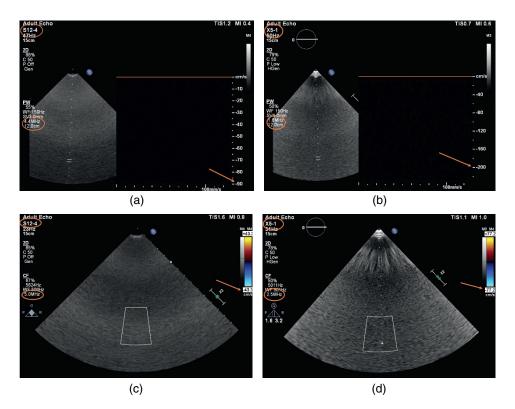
(a) This high-frequency transducer has a PW frequency of 4.4 MHz (orange circle) and an aliasing velocity (Nyquist limit) of 90 cm/s (arrow). (b) Lower transducer frequencies allow higher aliasing velocity (Nyquist limits). This PW frequency is 1.6 MHz (orange circle), which allows the maximum velocity to reach just over 200 cm/s (arrow) before aliasing occurs. (c) Using color flow Doppler, the transmitting frequency of 5 MHz (orange circle) in this image allows the Nyquist limit to reach 43.3 cm/s (arrow) before color starts aliasing. (d) A lower transmitting frequency of 2.5 MHz (orange circle) in this color flow Doppler image allows the aliasing velocity to increase to 77.2 cm/s (arrow) before the color signal aliases.
